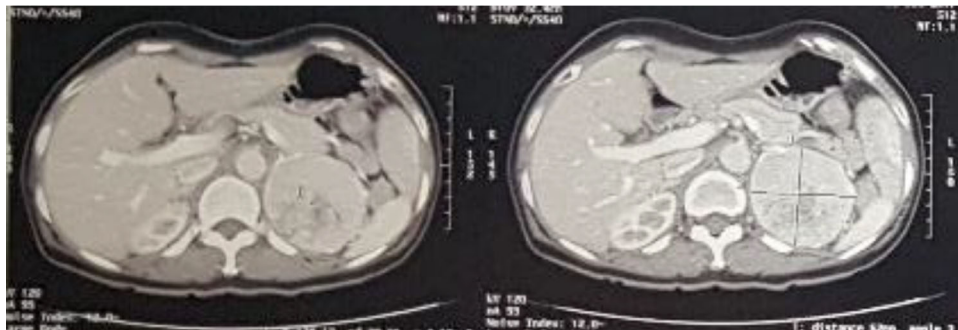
CT Scan showed a left mass suggestive adrenal tumor.
